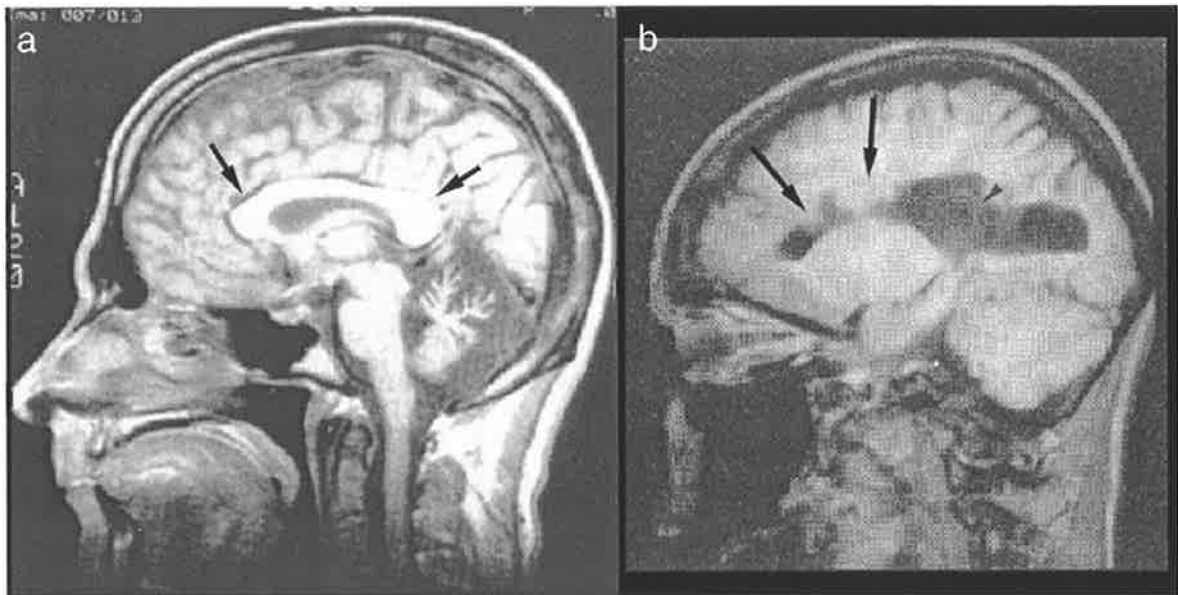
Magnetic Resonance Imaging of a sagittal Section through the human brain showing the different degrees of callosal agenesis. (a) The normal corpus callosum is seen as a large white structure (arrows). (b) An MRI showing agenesis of the corpus callosum, which is typical in Aicardi patients (arrows) (after Lassonde and Jeeves, 1994).
